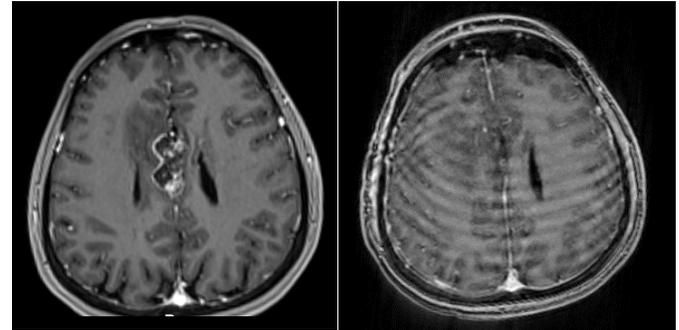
Pre-op MRI (left) and post-op MRI (right) showing near total tumor resection.
